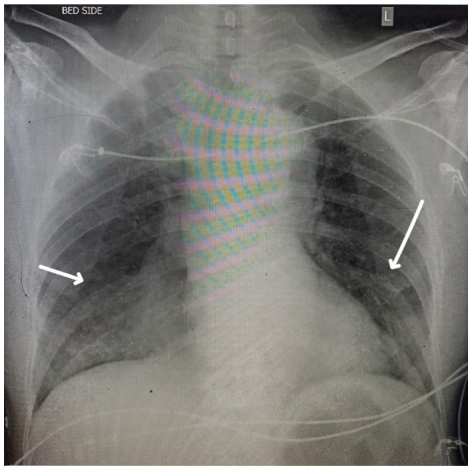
Chest X-ray AP view revealed bilateral lower zone haziness (right>left) indicated by white arrow (Image taken from the department of radiology, KMCH)
